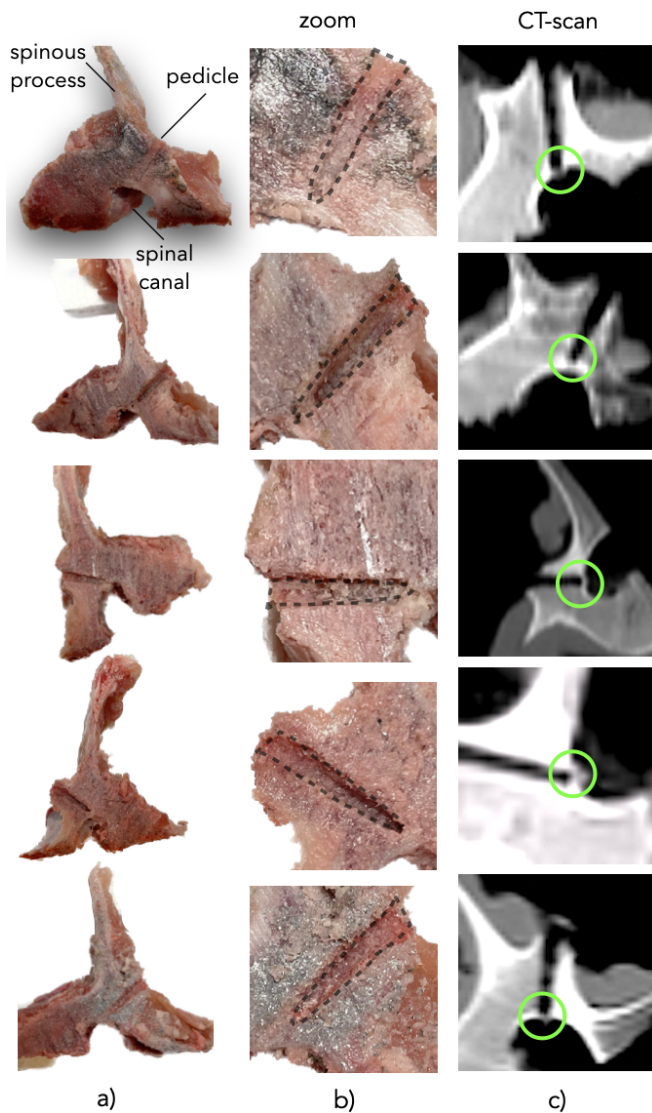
Sample of 5 (among a total of 24) vertebrae drilled experimentally using the developed robotic set-up and the proposed perforation detection algorithm. a) shows a global view of 5 vertebrae, b) the corresponding zoom on the drilled holes, and c) depicts the CT-scan images of the drilled holes. As can be seen (green circle) the drilling was stopped before the spinal canal, i.e. at the moment of deformation of periosteal tissue.
